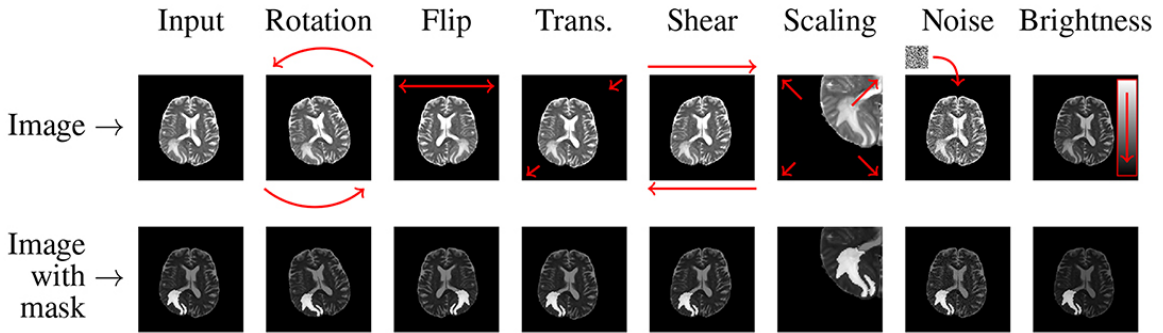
Examples of various data augmentation techniques applied to a T2w brain MRI [66]
